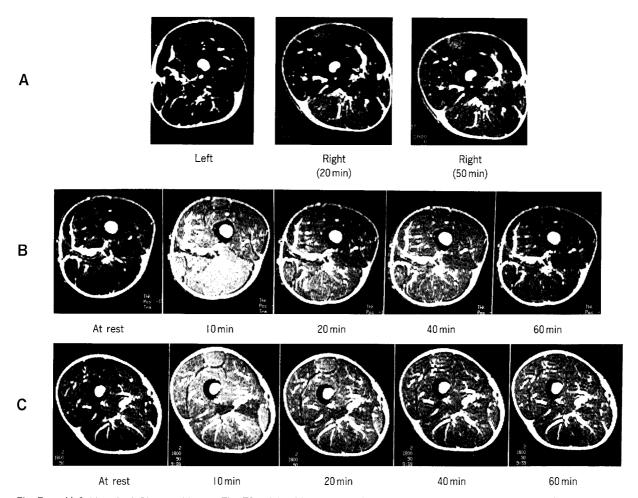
A) Subject 1: A 21-year-old man. The T2-weighted images revealed a marked increase in signal intensity for the musculus rectus femoris, semitendinosus and musculus gracilis 20 min after exercise. The intensity decreased by 50 min after exercise. B) Subject 2: A 22-year-old man. The T2-weighted images revealed an increase in signal intensity for all flexor and extensor muscles, in particular the flexor muscles. The signal intensity decreased with time. C) Subject 3: A 19-year-old man. The T2-weighted images revealed an increase in signal intensity for all flexor and extensor muscles, while the intensity for the adductor muscles was unchanged. The signal intensity decreased with time.
